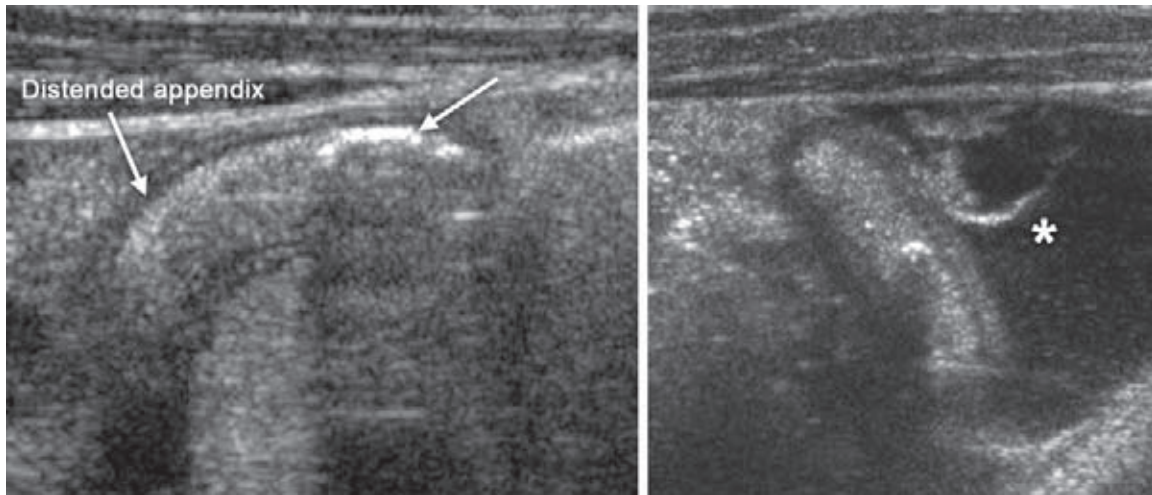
Ultrasound of a patient with complicated appendicitis shows a distended appendix with a phlebolith (arrow). The phlebolith is seen as an echogenic curvilinear structure with posterior acoustic shadowing. There is a focal fluid collection near the appendix (asterisk)
